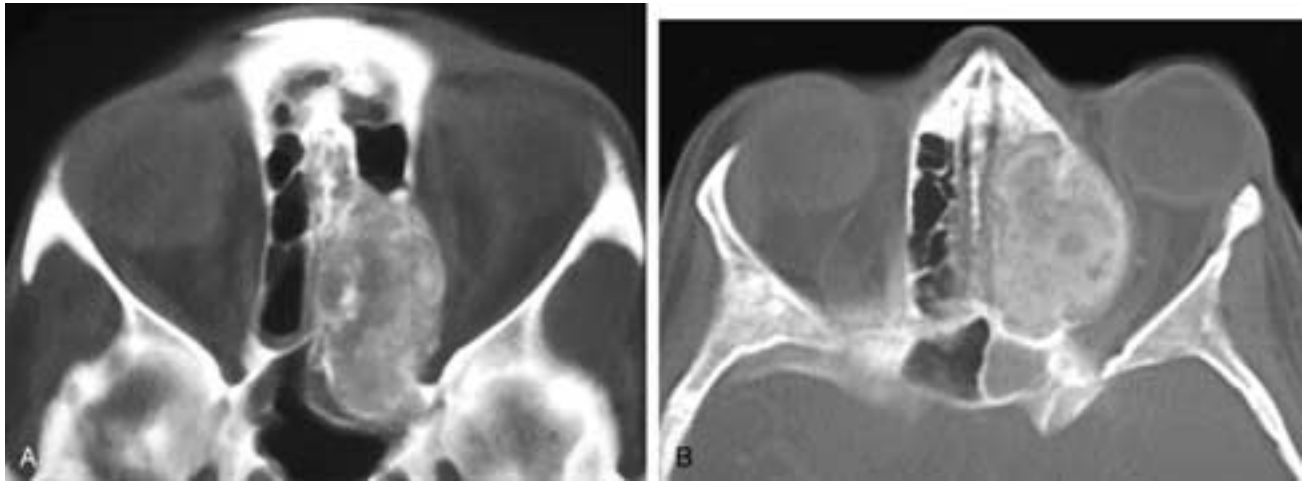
Axial CT scan (A) shows a “ground glass”-appearing bony process in the left ethmoid and sphenoid bones. There is encroachment into the left orbit. This patient had fibrous dysplasia. Axial CT scan (B) shows an expansile “ground glass”-appearing bony process in the left ethmoid complex. The left sphenoid sinus is obstructed by the process. Notice the similarity to A. This patient had an intraosseous meningioma.
